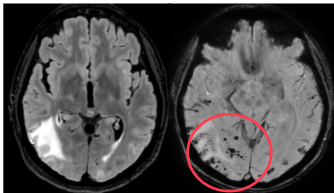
Axial FLAIR and SWAN during CAAri
